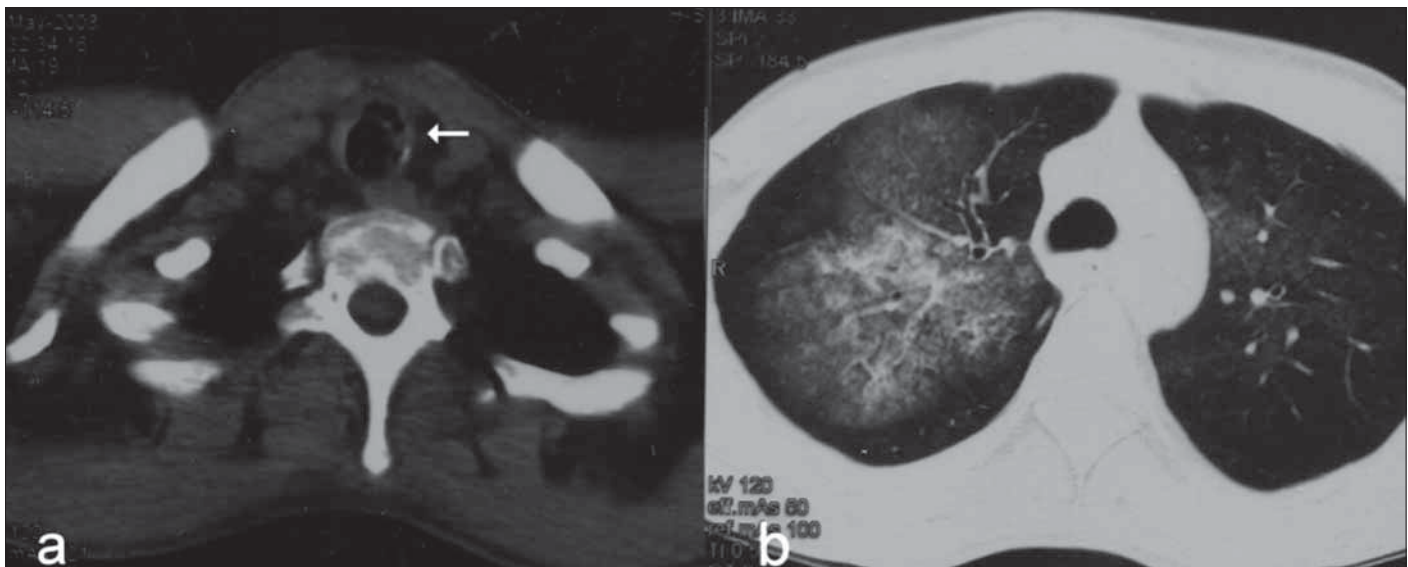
a) The neck CT scan shows a thickened anterior wall of the trachea, with internal air pockets, mucosal erosion and intraluminal soft tissue formations; b) The chest CT scan shows alveolar hemorrhage, particularly in the right lung
